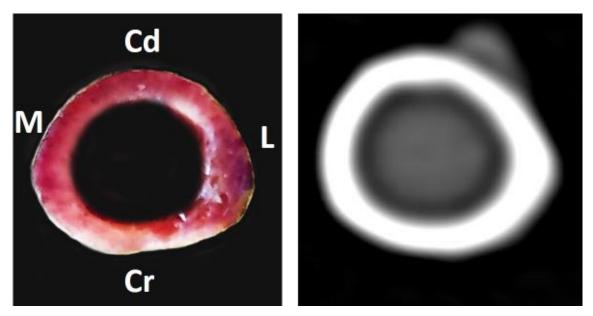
The cross-sectional view of right tibia (photograph and CT scan)
